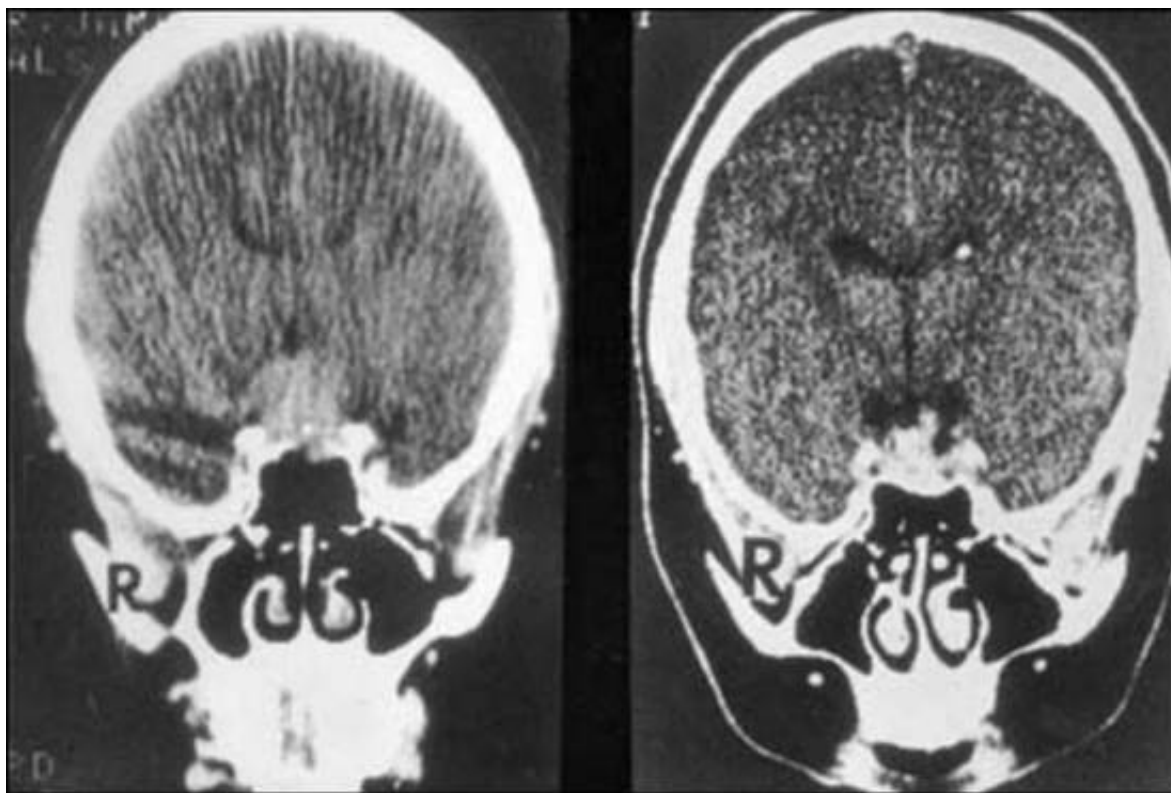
Coronal CT head scans before and during treatment with bromocriptine. Magnetic resonance imaging (T1 weighted with gadolinium enhancement) of a man harboring a large macroprolactinoma. A1(coronal view) A2 (sagittal view) before treatment and B1 (coronal view) and B2 (sagittal view), after one month of cabergoline (0,5mg thrice a week) treatment. The significant tumor shrinkage was paralleled by serum prolactin decrease from 6,600 ng/mL to 540 ng/mL and by visual improvement
